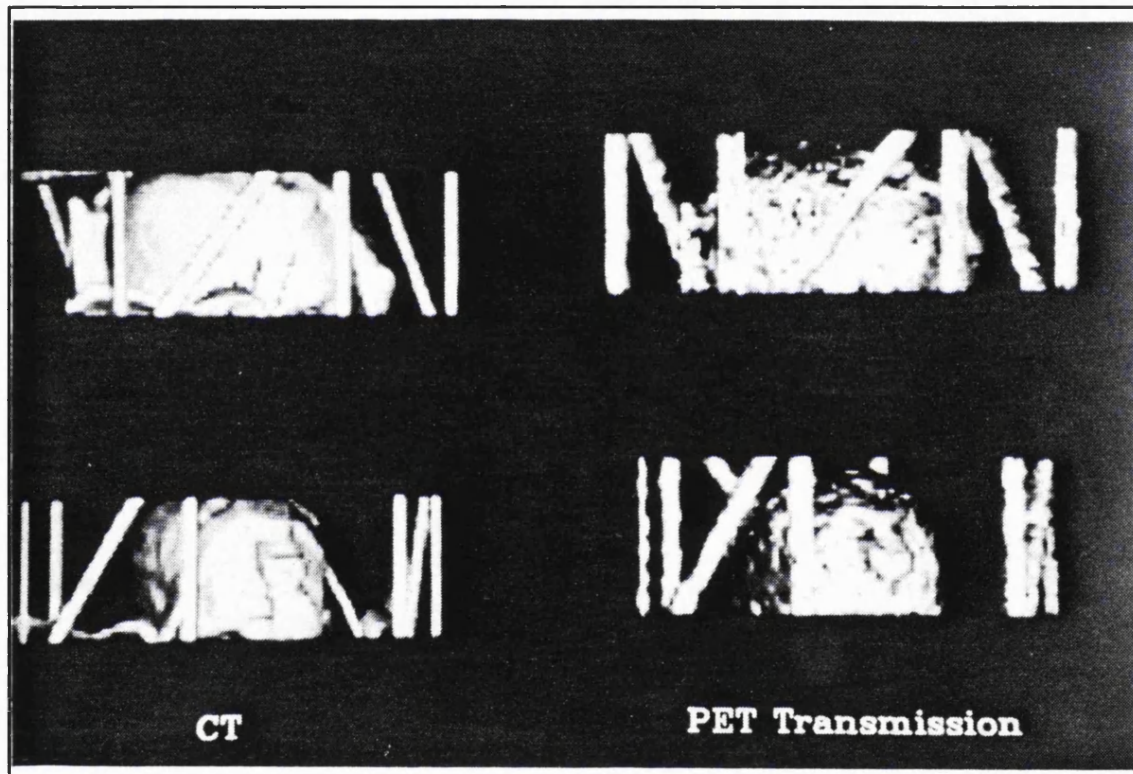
Geometrically correlated CT and Transmission PET volumes of patient in Relocatable Frame.
